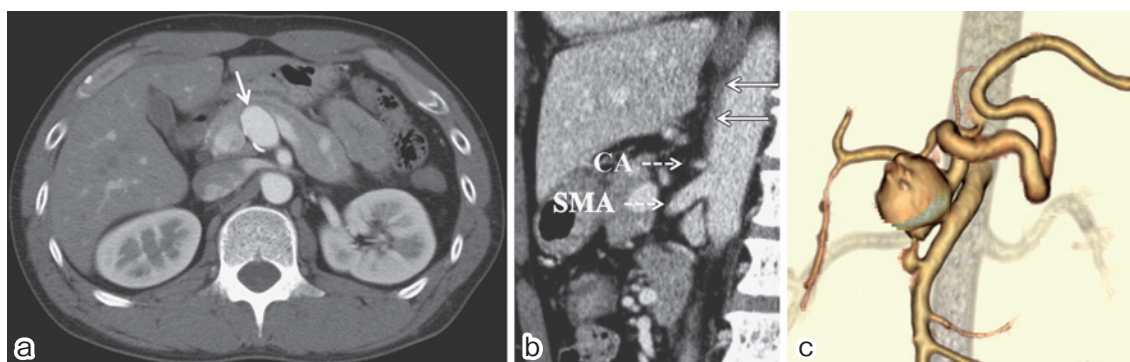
Computed tomography (CT) findings.
